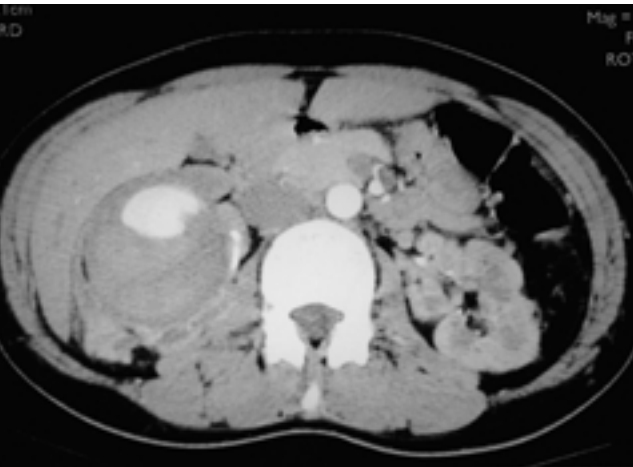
Contrast-enhanced axial CT scan shows a 6 cm-sized, high density lesion with partial contrast media filling in the upper pole of the right kidney.
